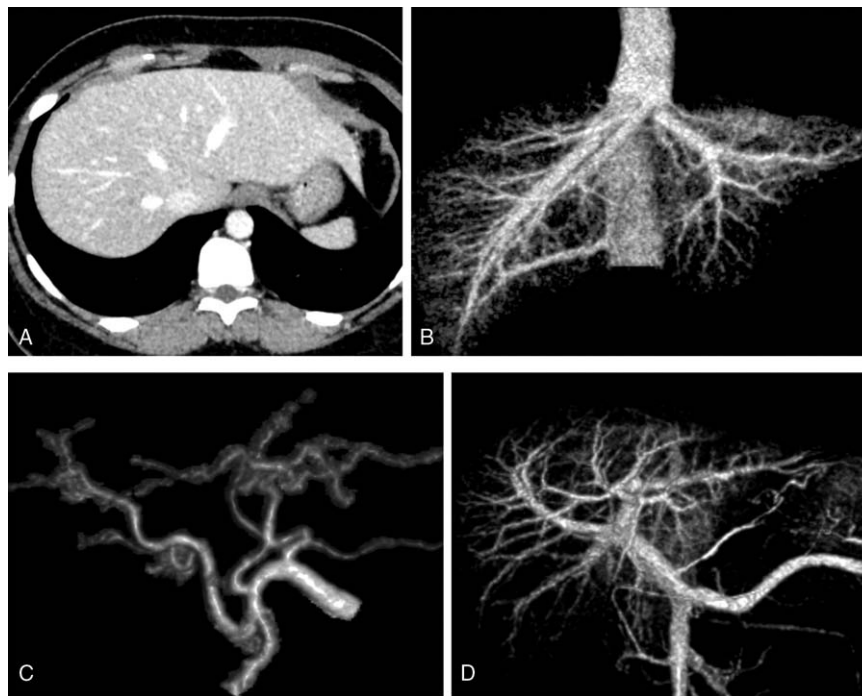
Thirty-year-old male donor candidate undergoing CT imaging under 100-kVp with IR (protocol B). Hepatic vein is clearly identified on the axial CT (A) and volume-rendering 3D images (B), providing helpful information for surgery. The hepatic artery and portal vein are also clearly visualized on volume-rendering 3D images (C and D, respectively). Each visual score (hepatic artery, hepatic vein, and portal vein) is excellent (score 5). CT=computed tomography, IR=iterative reconstruction.
